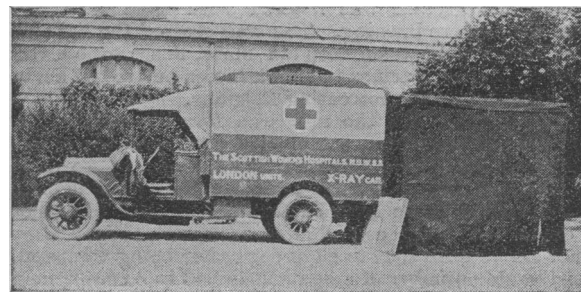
X-ray car with tent.
